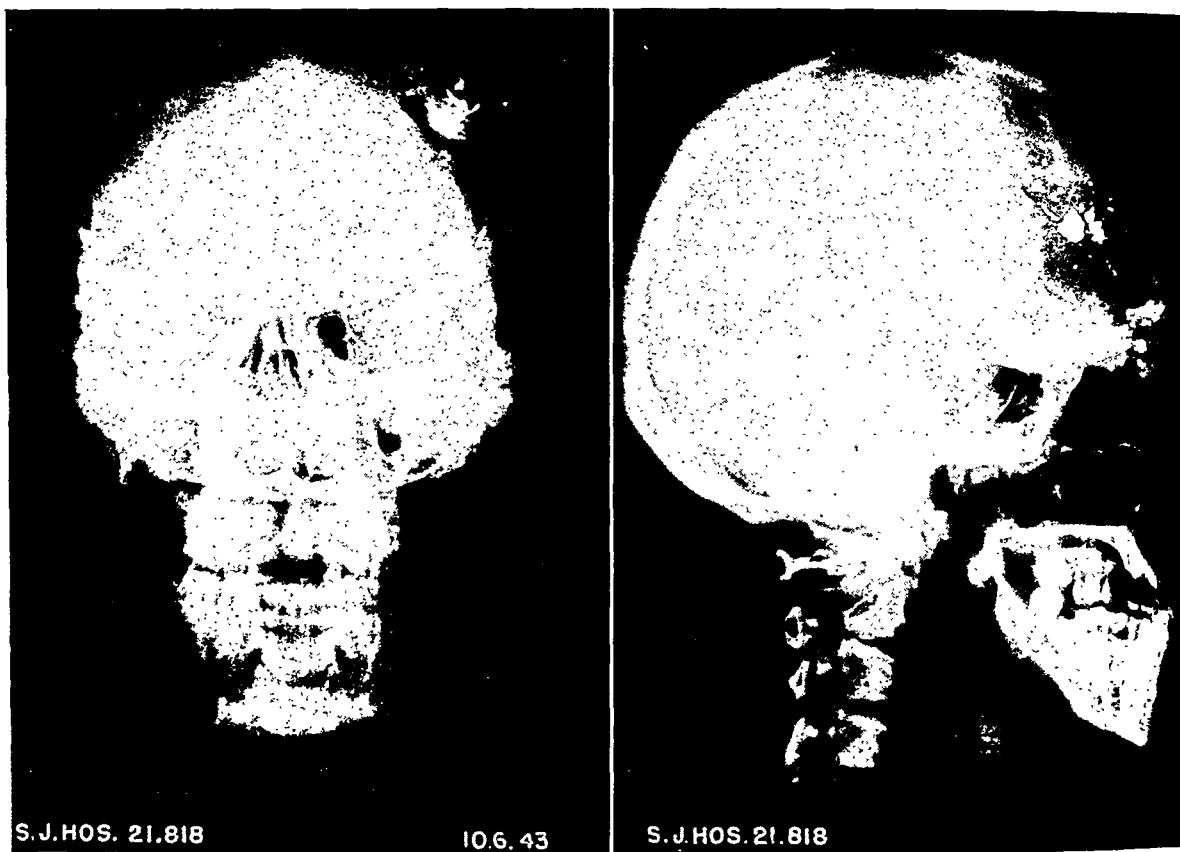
Roentgenograms made Oct. 6, 1943, about four weeks after injury, showing metallic fragments and stellate fractures. No intracranial air is shown.
